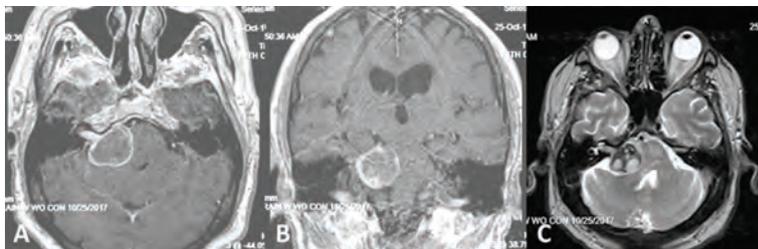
MRI of the patient from Case 2 on warfarin therapy due to artificial heart valve, showing enlarged VS on the left side with intratumoral bleeding. (A) T1 weighted axial MRI, (B) T1 weighted coronal post-contrast MRI of the head, and (C) axial T2 weighted MRI of the head show intratumoral hemorrhage.
